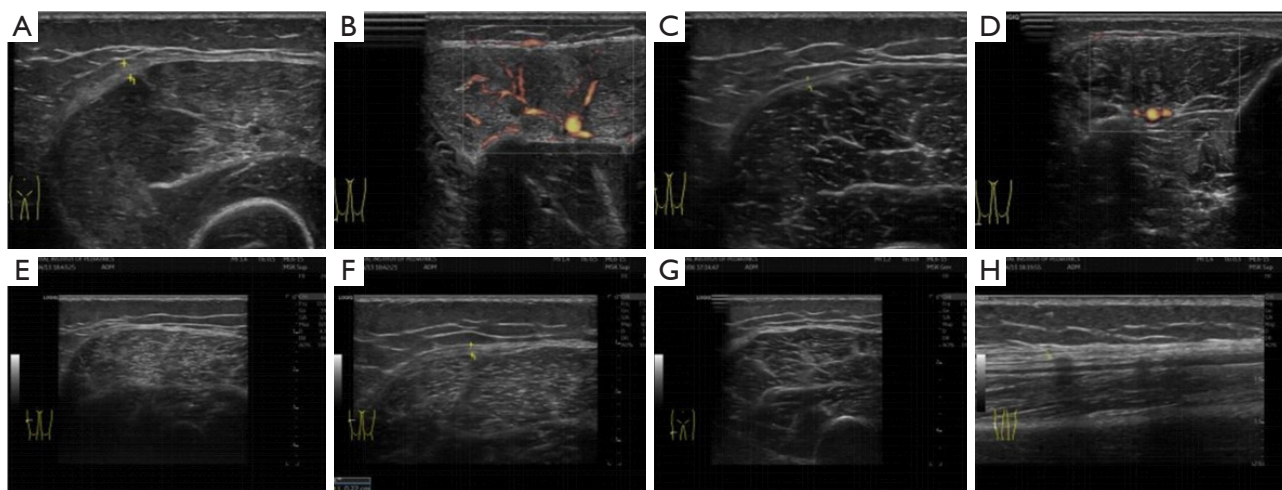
Muscle ultrasounds of active-phase JDM patients. (A) Increased muscle EI and thickened fascia. (B) Abundant blood flow signals. (C,D) Muscle ultrasounds of a stable-phase JDM patient. (C) Normal muscle EI and no thickening of the fascia. (D) No increased fine blood flow. (E-H) The follow-up MRI of patient 1. (E,F) The first examination in which the muscle EI was increased and the fascia was thickened. (G) Normal muscle EI after 8 months of re-examination. (H) Early fascial calcification found in one examination. JDM, juvenile dermatomyositis; EI, echo intensity; MRI, magnetic resonance imaging.
